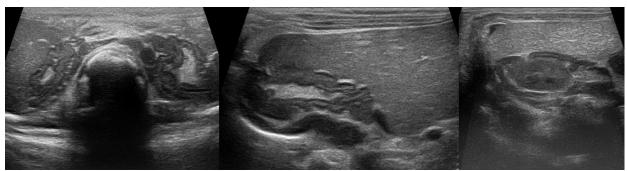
Ultrasonographic changes of adrenal glands in infants with Congenital Adrenal Hyperplasia: A) Bilateral cerebriform view of the enlarged adrenal gland. B and C) Before and after treatment views of right adrenal: decreased size and disappearing cerebriform pattern of the adrenal gland is obvious
